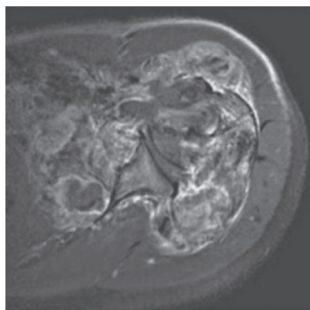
Magnetic resonance imaging of shoulder showing large soft tissue mass (Courtesy: Seeman. Consultant Radiologist, Coimbatore, Tamil Nadu).
